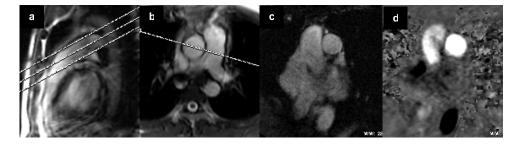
An example of MRI resting VO2 measurement. Male, 42 yrs a-b. MPA localization. c. Mutiple-echo T2 prep images (only the 1st echo image shown here). d. MPA PC image. BW=65.8 kg, Q=5197.19 ml/min, MPA %O2=81%, [Hb]=0.16 g/ml, Cm=1.36 ml per g Hb.
